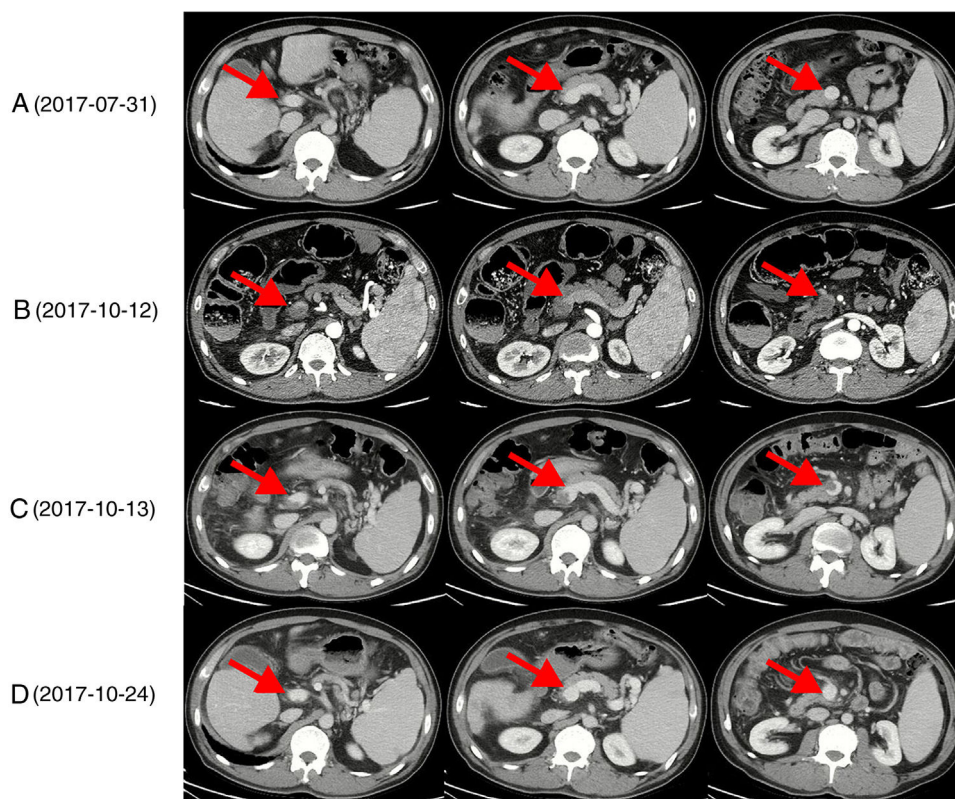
Computed tomography images in this patient. Panel A: Contrast-enhanced computed tomography performed on July 31, 2017 demonstrated patent main portal vein and superior mesenteric vein (red arrow). Panel B: Computed tomography angiography performed on October 12, 2017 demonstrated complete occlusive main portal vein and superior mesenteric vein (red arrow). Panel C: Contrast-enhanced computed tomography performed on October 13, 2017 demonstrated partially recanalized main portal vein and superior mesenteric vein (red arrow). Panel D: Contrast-enhanced computed tomography performed on October 24, 2017 demonstrated completely recanalized main portal vein and superior mesenteric vein (red arrow).
